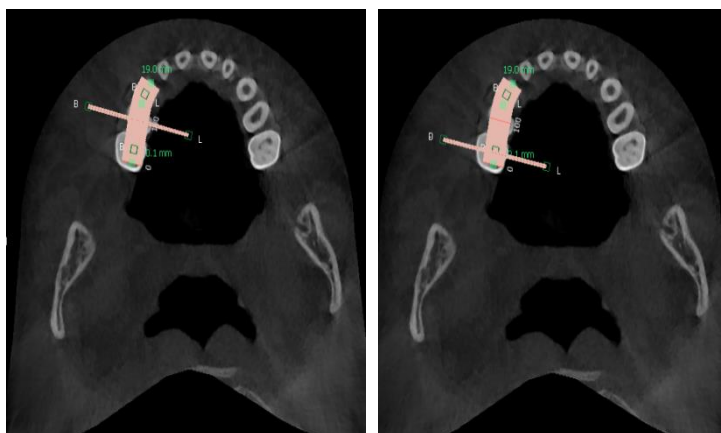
Axial CBCT section of maxillary right 1st primary molar (A) and right 2nd primary molar (B)
